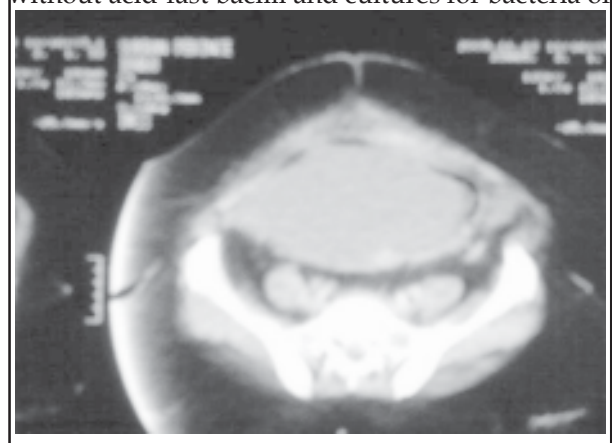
An abdominal CT scan showed a 20 by 10- by 5-cm fluid collection in the abdomen.
